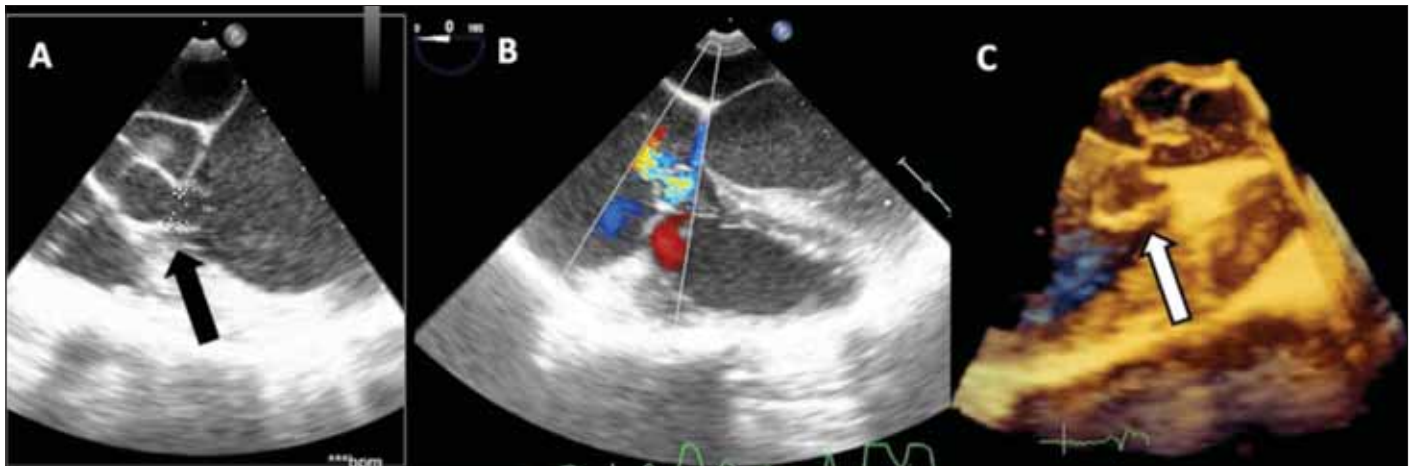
2D transthoracic (A), 2D transesophageal (B) and 3D transesophageal (C) echocardiography views depicting ruptured sinus Valsalva with regurgitation into the right atrium
